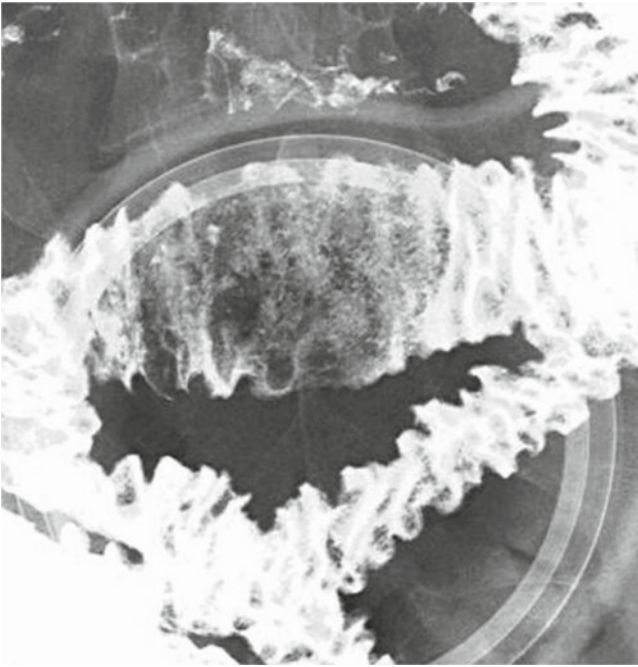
Radiography. Under compression, enlargement of the folds and tiny barium flecks were evident
